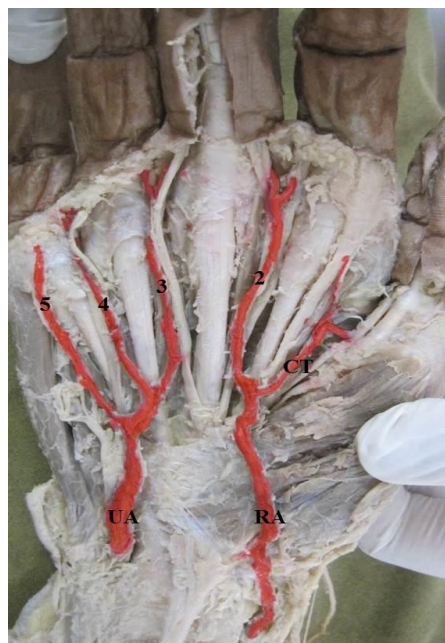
Right hand showing an Incomplete SVA (radio-ulnar type without communication between radial and ulnar arteries). UA – Superficial branch of ulnar artery; RA – Superficial branch of radial artery; 2, 3, 4, - 2nd, 3rd and 4th common digital arteries; 5 – Proper digital artery; CT – common trunk for arteria princepspollicis and arteria radialisindicis.
